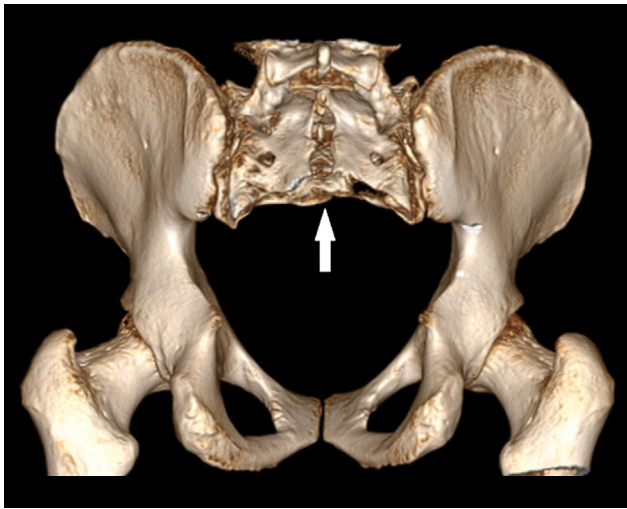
Three-dimensional CT reconstruction after surgery, posterior view. Resection of the sacrum at the level of the S3 vertebra (arrow).
